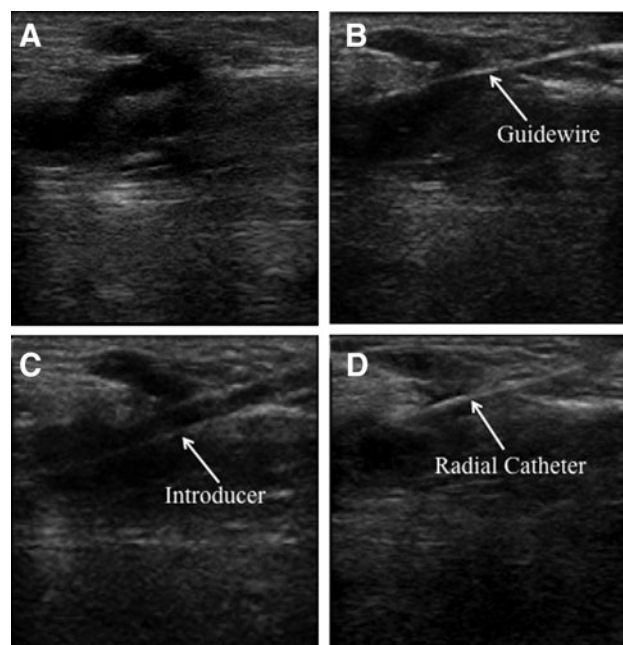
(A) Doppler image of incompetent calf perforating vein. Intraoperative Doppler image of the (B) guide wire, (C) introducer, and (D) radial catheter of treating the target perforator.
